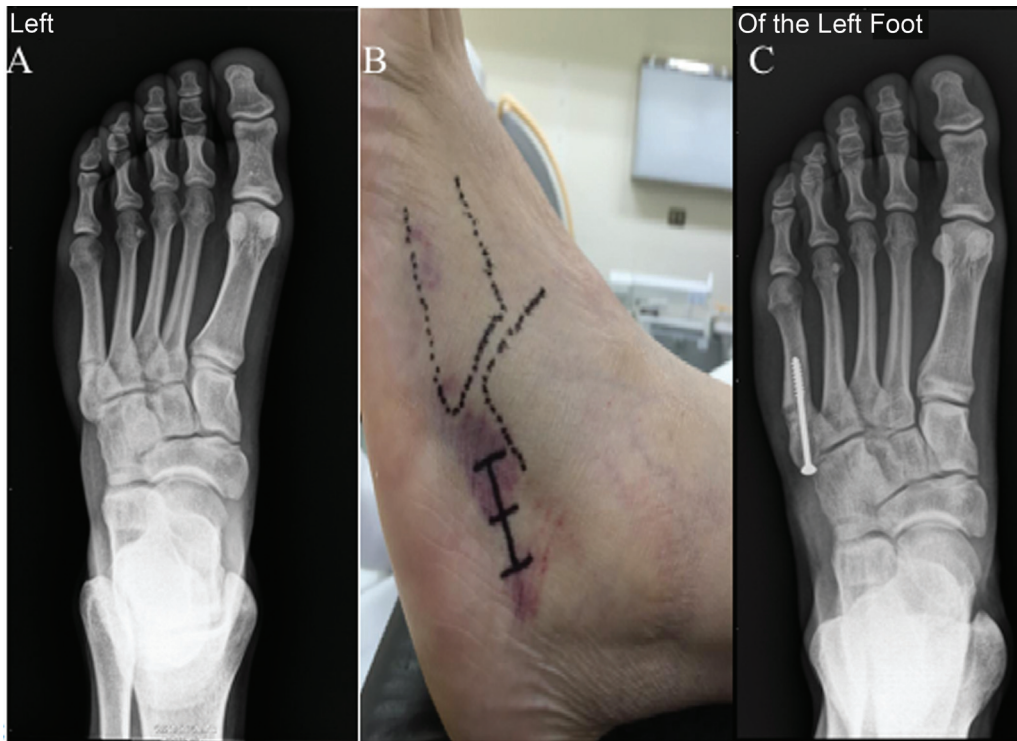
(A) Radiograph showing a fracture at the zone 3 of the base of the fifth metatarsal bone. (B) Percutaneous surgical approach. (C) The most used screw length was of 45 mm.
